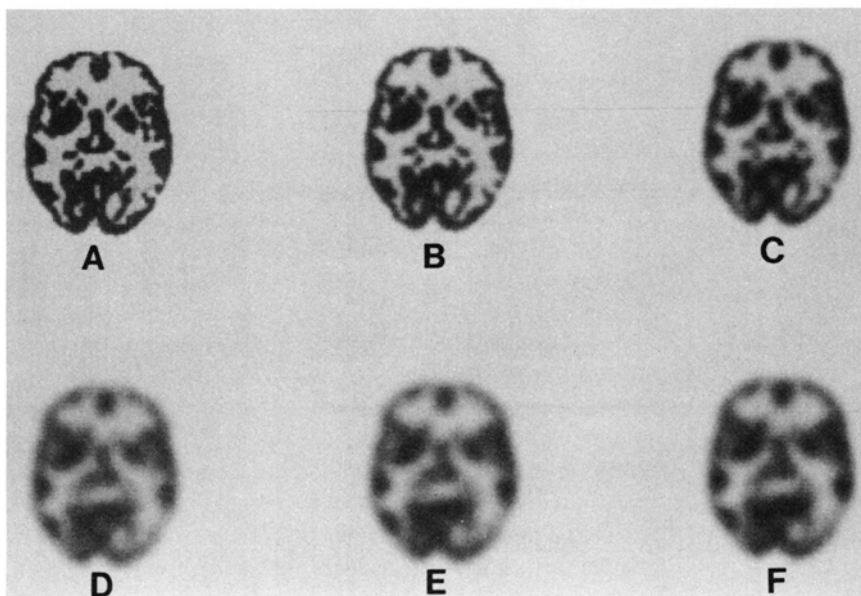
SPECT image quality as a function of pixel size. (A) 2 mm/pixel, (B) 3 mm/pixel, (C) 4 mm/pixel, (D) 5 mm/pixel, (E) 6 mm/pixel, (F) 7 mm/pixel. As pixel size increases, it becomes a significant factor in resolution degradation.
